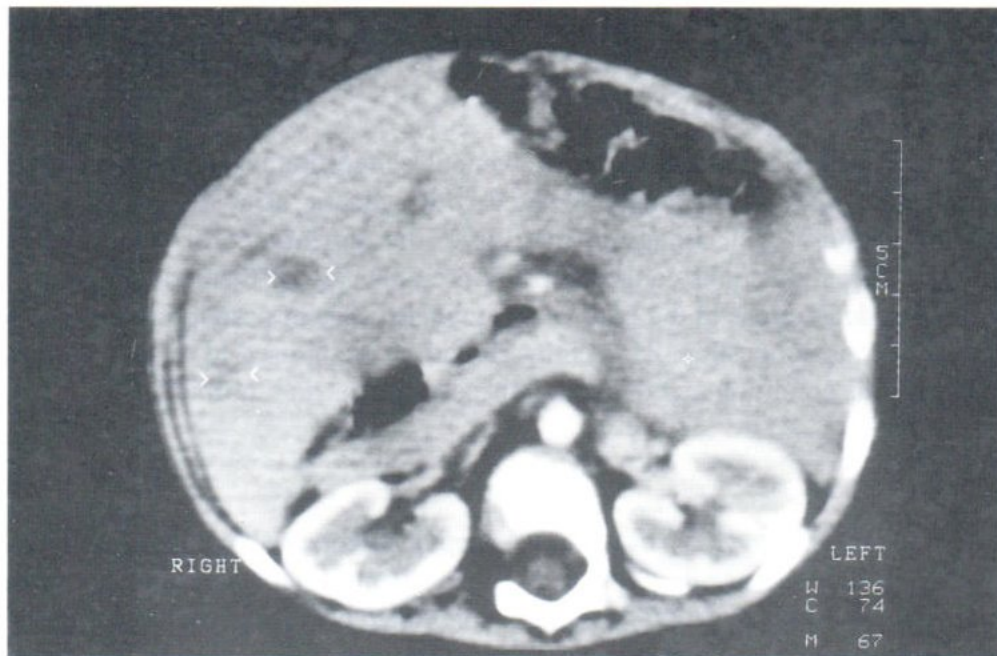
Axial CT scan of the abdomen after IV contrast enhancement shows hepatomegaly with multiple hypodense areas within the liver (arrowheads).
